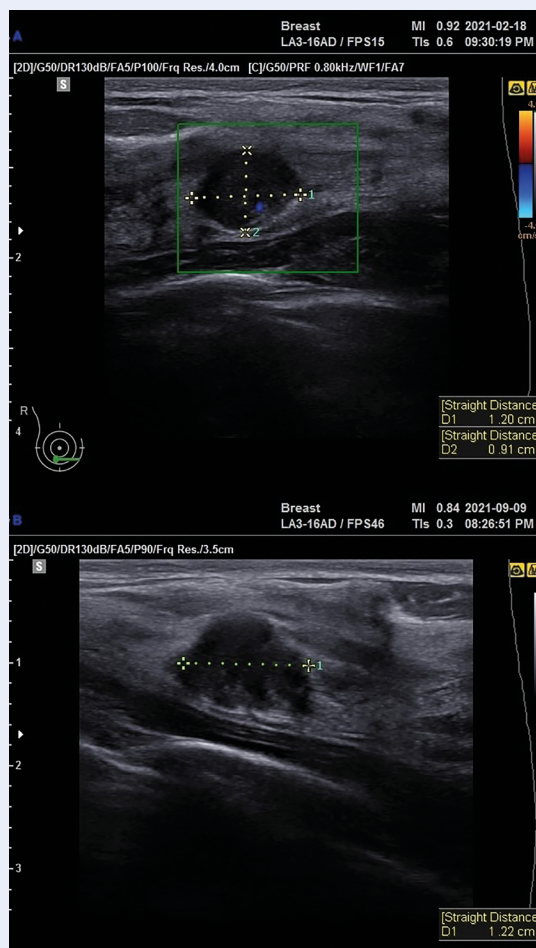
Ultrasound images (B-mode presentation) of the same lesion; A. Relatively well delineated lesion, BI-RADS 3; B. Slightly ill-defined margins, BI-RADS-4b
